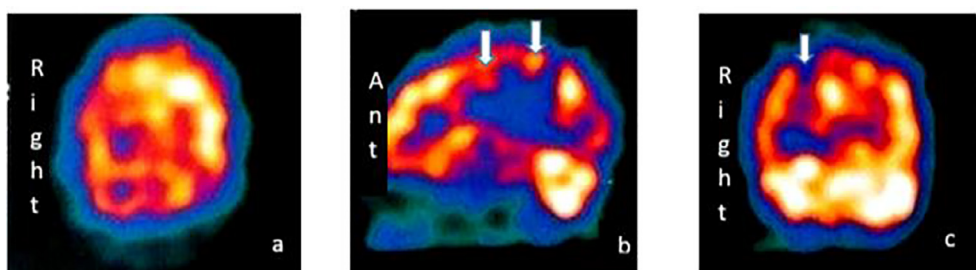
The HMPAO-SPECT images (a, transaxial; b, sagittal and c, coronal cuts) show multiple brain hypo-perfusion areas involving the fronto-parietal and parieto-occipital regions, predominantly affecting the right side. According to General Electric color strip code, the color may vary from deep yellow (denoting normal blood flow) to black (denoting necrosis and absence of blood flow).
